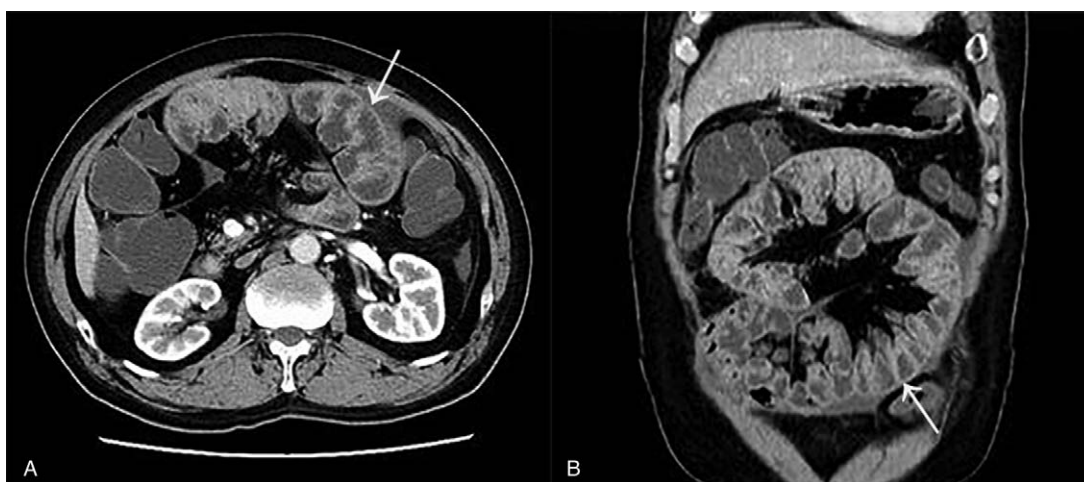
Computed tomography images showed the small intestine was restricted to the central part of the abdomen in a typical cocoon pattern (arrow), producing a “cauliflower” appearance. (A) Axial slice; (B) multiplanar coronal reconstruction.
